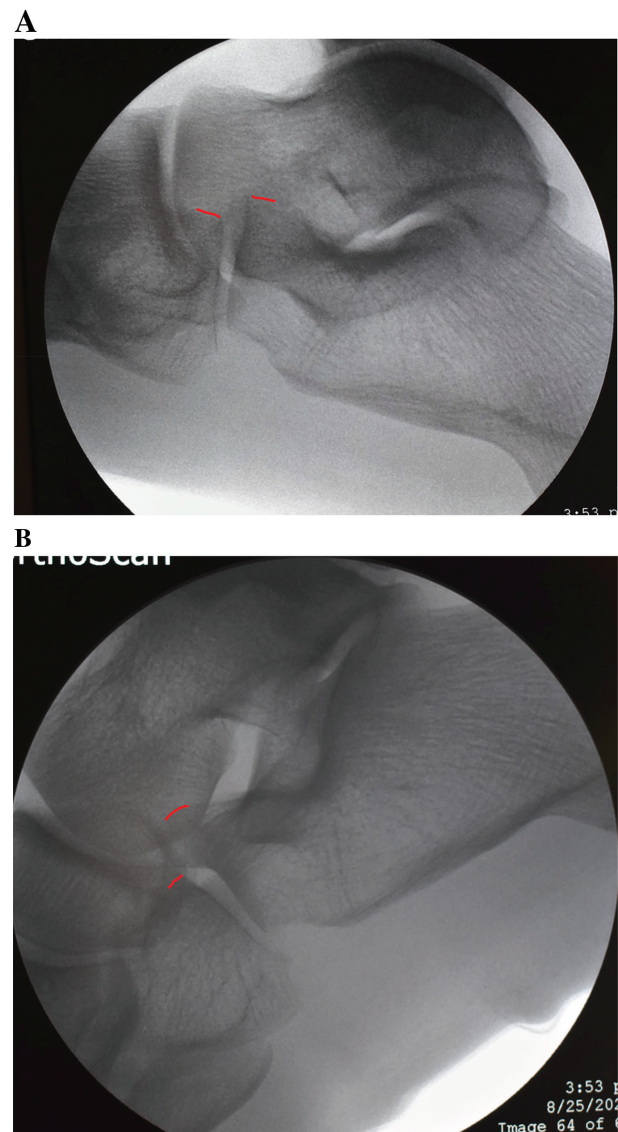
Lateral C-arm radiographs of the foot in a young adult with hypermobile flatfeet (A) with dorsiflexion force and (B) with plantarflexion force. Note the difference in the relative positions of the dorsal cortex of the calcaneus and cuboid (red lines).
